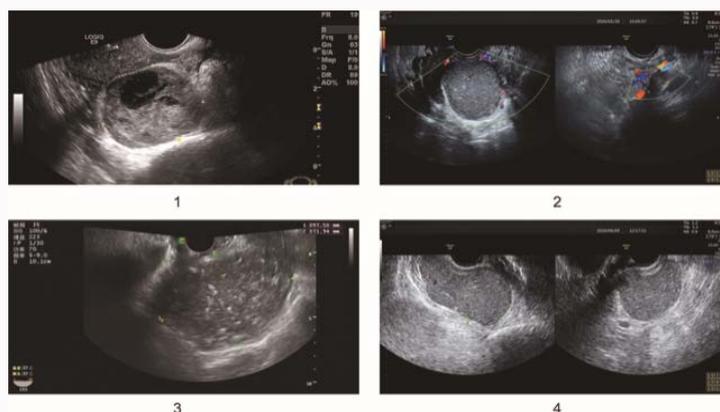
The benign presacral tumors of patients involved in Doppler ultrasound.
